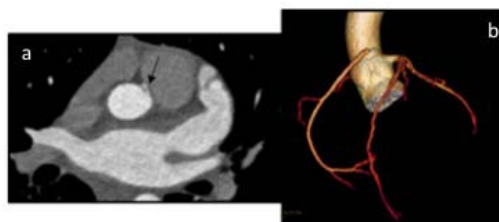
Computed tomography with a) contrast and b) volume reconstruction showing anomalous origin of the right coronary artery from the left coronary sinus with inter-arterial course between the aorta and the pulmonary trunk (arrow).
